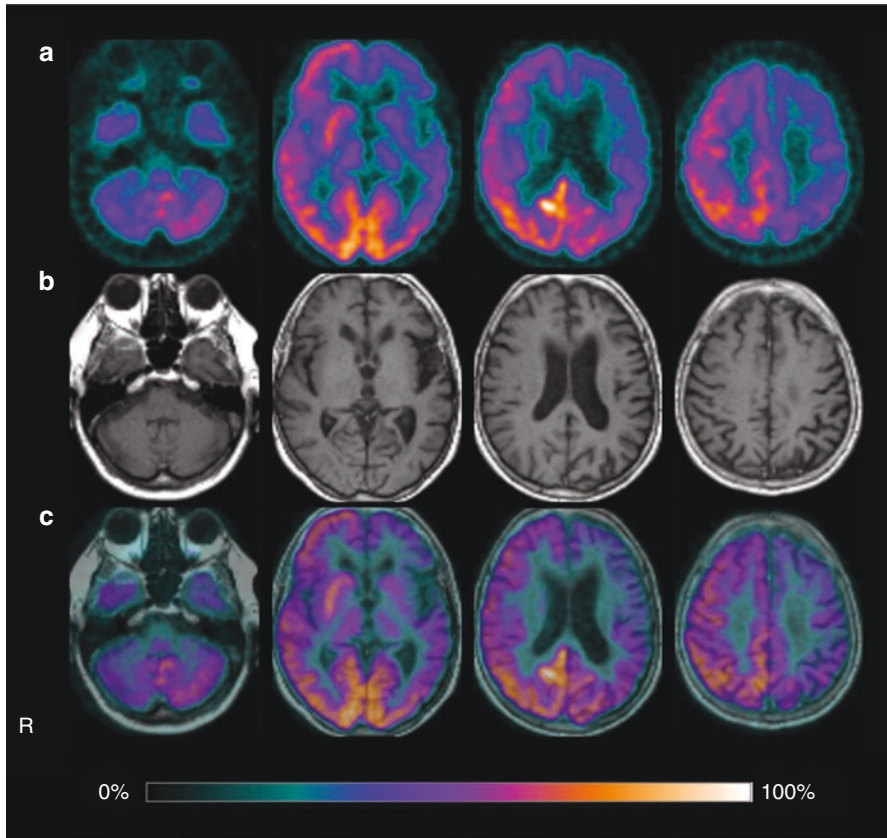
(a) FDG-PET, (b) MRI, and (c) fused PET/MR images from a representative case of CBD. Decreased metabolism can be observed in the cortical regions (frontal, temporal, and parietal cortex, including precuneus) and basal ganglia of the left hemisphere. The degree of hypometabolism seemed to be more severe than the atrophy observed at the MRI. In this case hypometabolism of the cerebellar cortex of the contralateral hemisphere, indicating cerebellar diaschisis, can be observed. The PET examination was performed at the Biostructure and Bioimaging Institute, National Research Council and University Federico II, Naples, Italy
